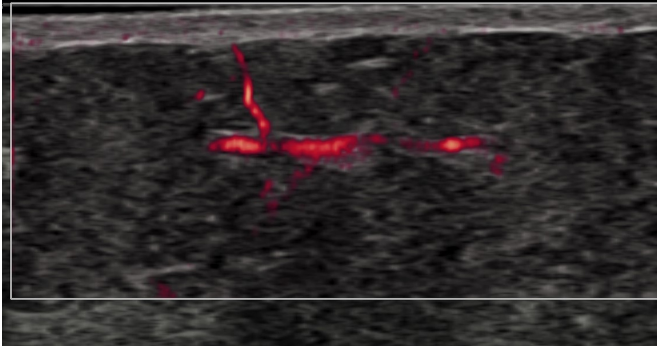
Hypodermis vascularization. Power-Doppler scan. Vessel branches are typically seen pointing to the surface and stopping at the dermis-hypodermis edge.
